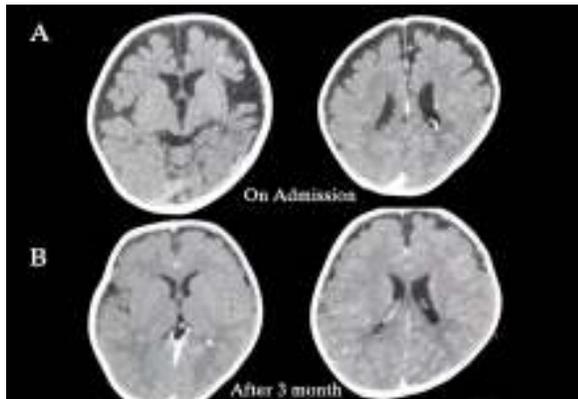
(A) Brain CT scan on admission showed sign of generalized atrophy involving mainly fronto-parietal lobe. (B) Brain CT scan after 3 month shows marked improvement
